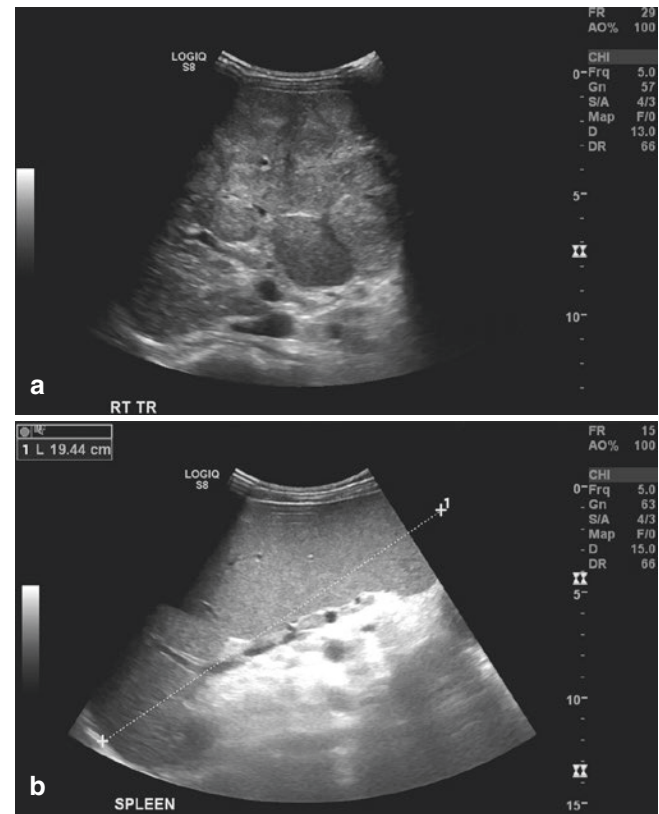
(a, b) Ultrasound axial sections of the liver and coronal section of the spleen reveal irregular heteroechoic liver with nodular surface and splenomegaly in keeping with cirrhosis and portal hypertension in CFLD
